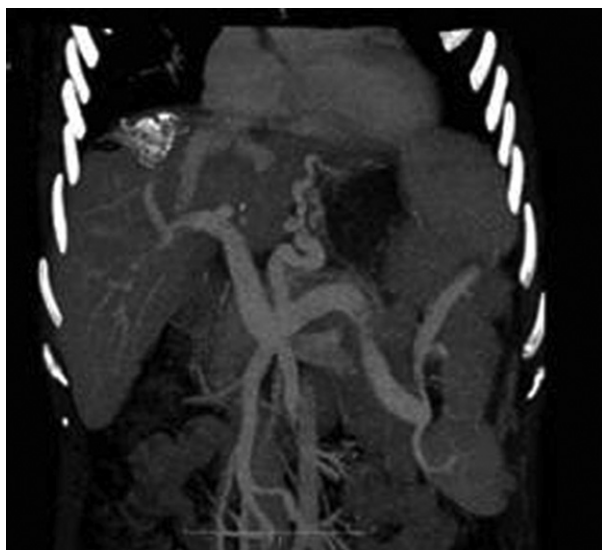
Post-operative 3rd year CT angiogram of the transplanted liver. A calcified hydatid cyst was at the dome of the liver.
